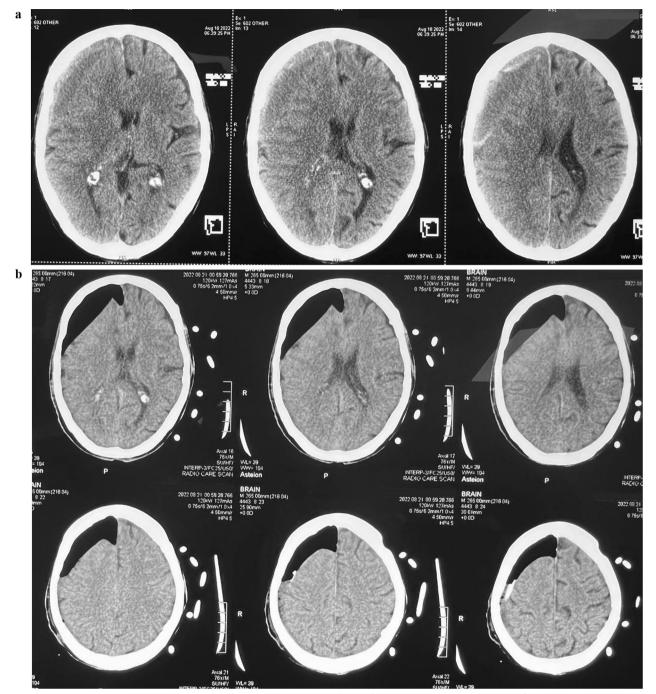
a CT showing chronic subdural hematoma on the right side with midline shift. b CT showing good evacuation of the hematoma with the drain tip in the subdural space with improvement of midline shift
